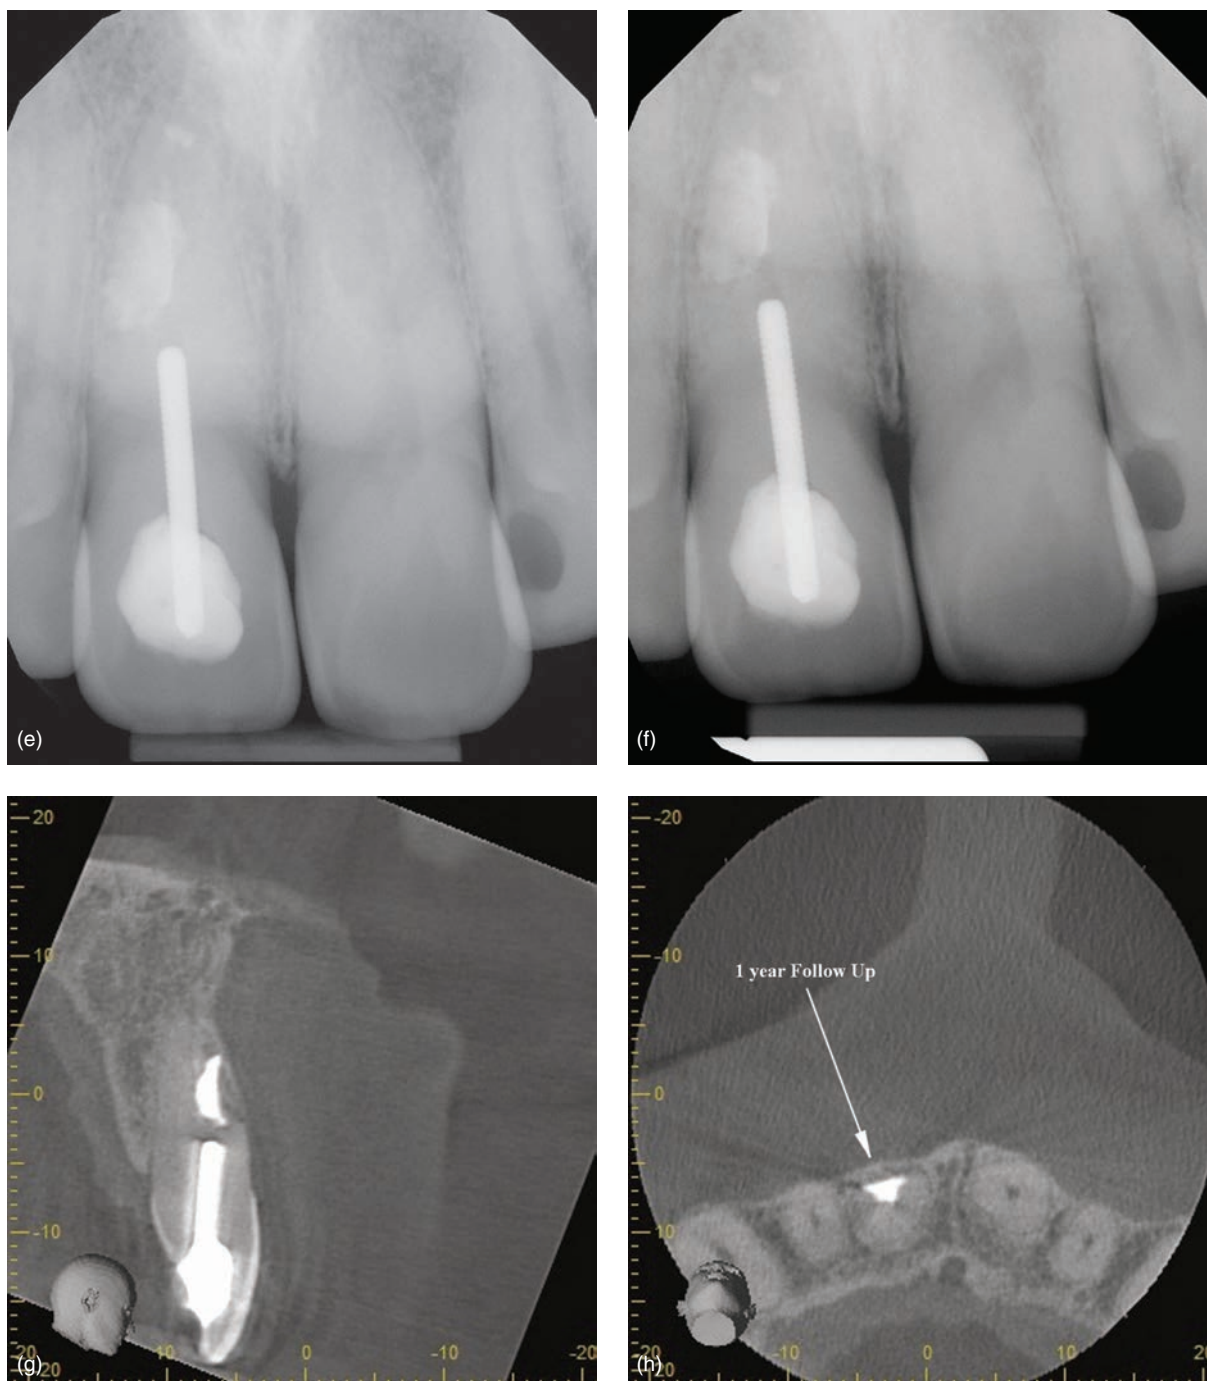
(Continued) (e) Postoperative radiograph. (f) One year follow-up radiograph. (g) Coronal view showing cortical bone healing around the root repair material at 1 year follow-up. (h) axial view showing cortical bone healing around the root repair material at 1 year follow-up.
